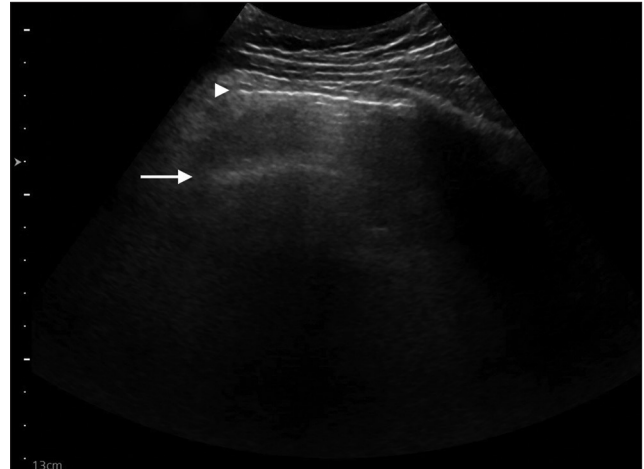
Ultrasound image of the periumbilical region of the abdomen. A-lines (arrow), parietal peritoneum (arrowhead)
